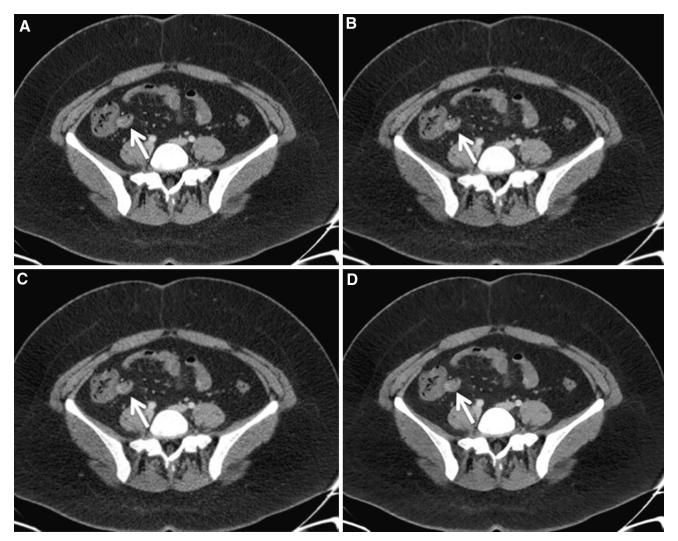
Patient weighing 255 pounds with subtle, active inflammatory neo-terminal ileal disease without luminal narrowing using CARE kV at full and half-dose, and reconstructed with filtered back projection (FBP) and iterative reconstruction (sonogram-affirmed iterative reconstruction or SAFIRE). Images at full dose (A), half-dose reconstructed with FBP (B), half-dose reconstructed with sonogram-affirmed SAFIRE, strength 3 (C), and half-dose reconstructed with SAFIRE, strength 4 (D). Tube voltage selected was 120 kVp; quality reference mAs was 220. The CTDIvol at full dose was 38.27 mGy (half-dose = 19.13 mGy) (SSDE full dose =
